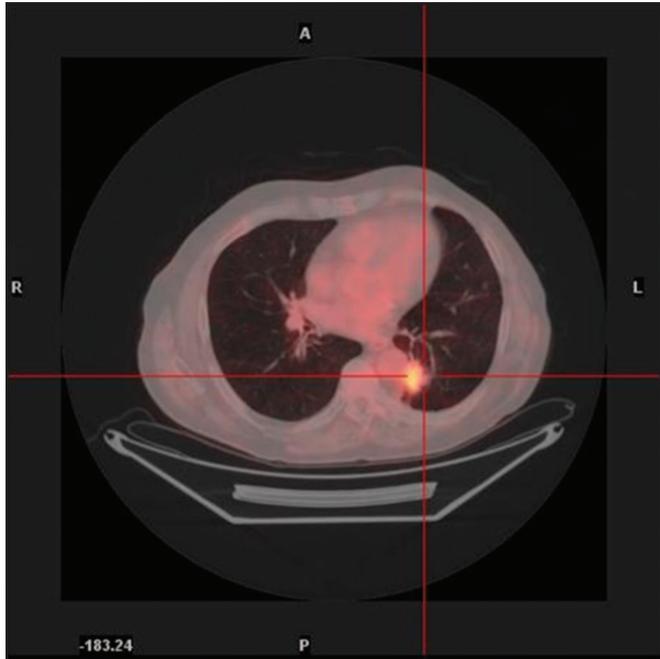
Positron emission tomography computed tomography showed a hypermetabolism of the left hilar opacity (SUV 3 g/ml).
